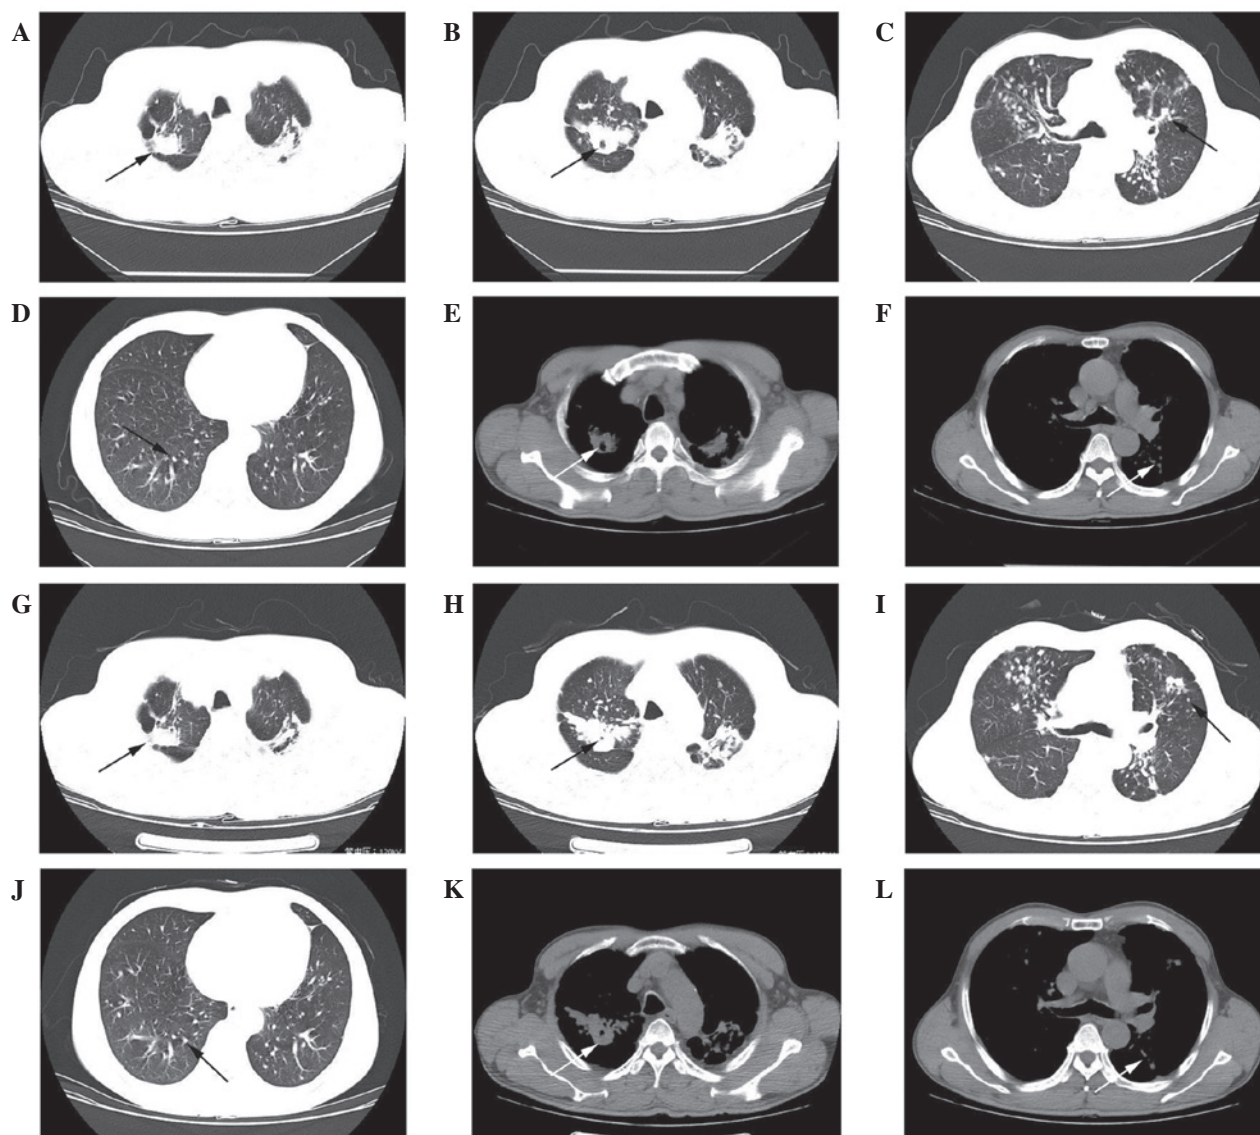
Chest computed tomography scan of the patient upon admission (A-F) and 6 months later (G-L). Confluent opacities in the bilateral upper lobes (A) upon admission and (G) 6 months later. One area of focal cavitation in the right upper lobe (B) upon admission and (H) 6 months later. Nodular opacities in the bilateral upper lobes (C) upon admission and (I) 6 months later. Nodular opacities in the bilateral lower lobes (D) upon admission and (J) 6 months later. One area with focal cavitation in the right upper lobe, shown in the mediastinal window, (E) upon admission and (K) 6 months later. Nodular opacities in the bilateral upper lobes, shown in the mediastinal window, (F) upon admission and (L) 6 months later.
